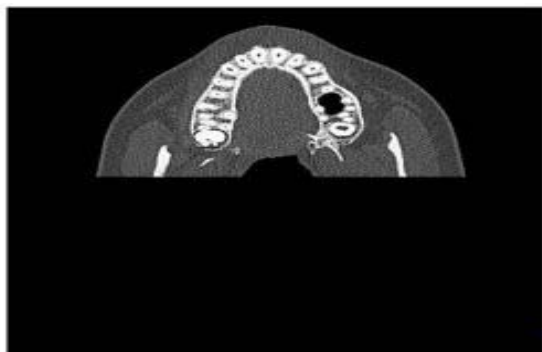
CT image after putting zero to the redundant pixel.
